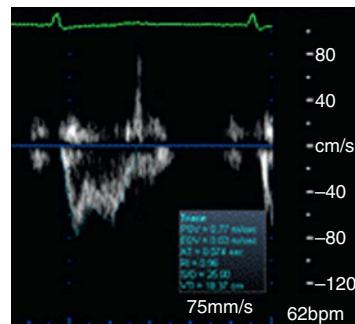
From Opotowsky AR, Clair M, Afifalo J, et al. A simple echocardiographic method to estimate pulmonary vascular resistance. Am J Cardiol. 2013;112:873–882.
